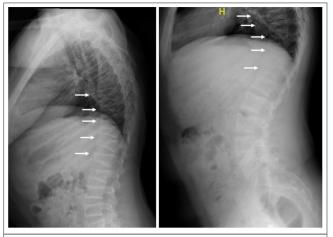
Lateral lumbar spine radiograph of a boy with spondyloocular syndrome. Left panel: At the start of treatment. All vertebrae have compression fractures. Right panel: 3 years of pamidronate treatment.
